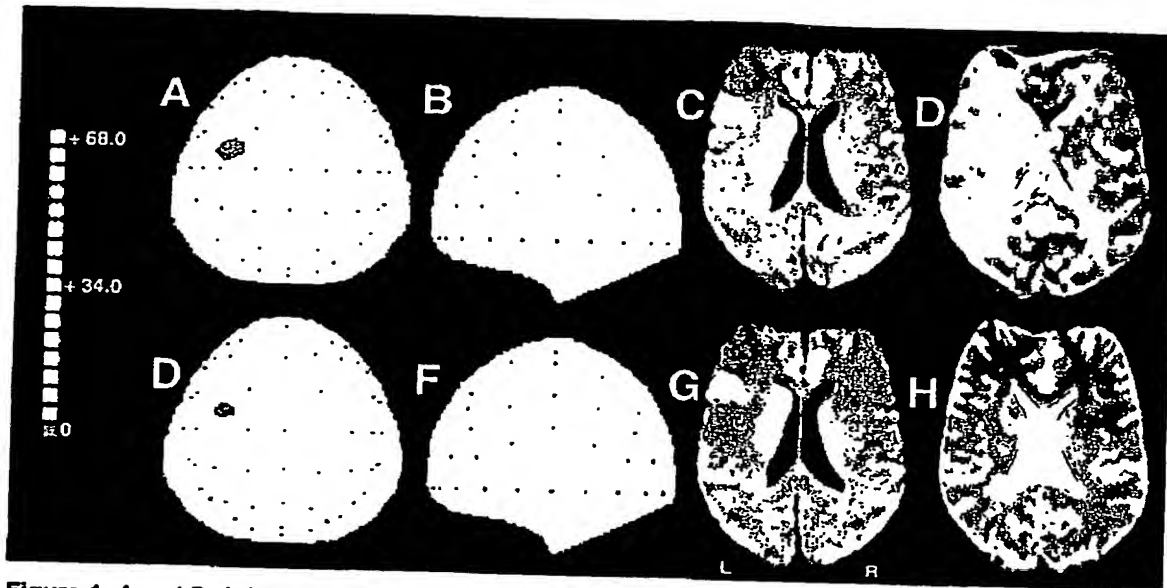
A and B: Axial and sagittal EEG Scalp Topographic Delta Power maps acquired 7 hours after onset of symptoms; C: initial DWI (6 hours after onset of symptoms); D: initial MTT map; E and F Axial and sagittal EEG Scalp Topographic Delta Power maps acquired 13 hours after onset of symptoms; G: 15 hours DWI scan and H: follow-up T2 MRI.
